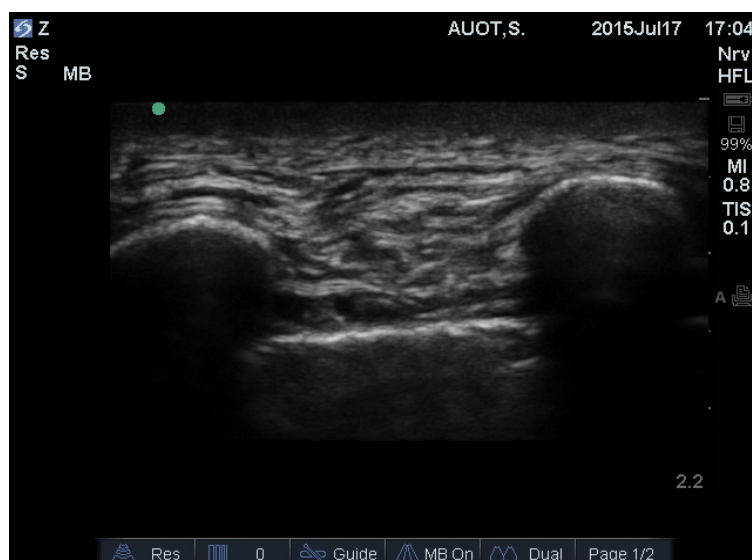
Ultrasound image of left paravertebral space with the transducer in the sagittal plane.
